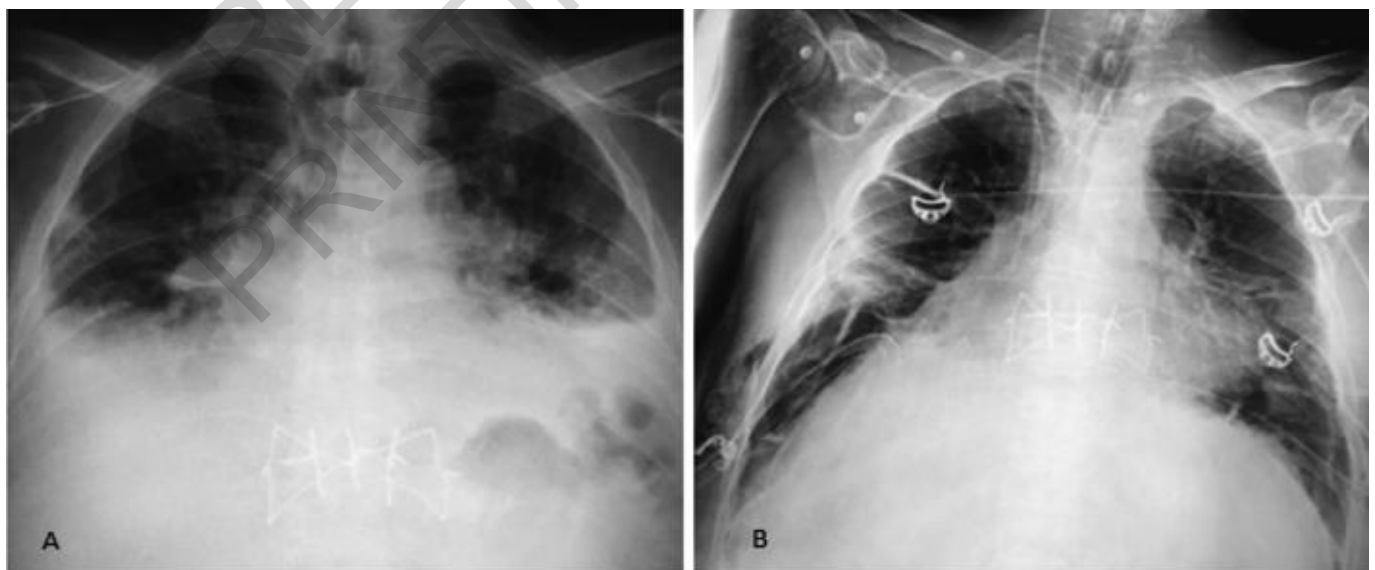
A) Preoperative chest X-ray, B) Postoperative first-day chest X-ray.
